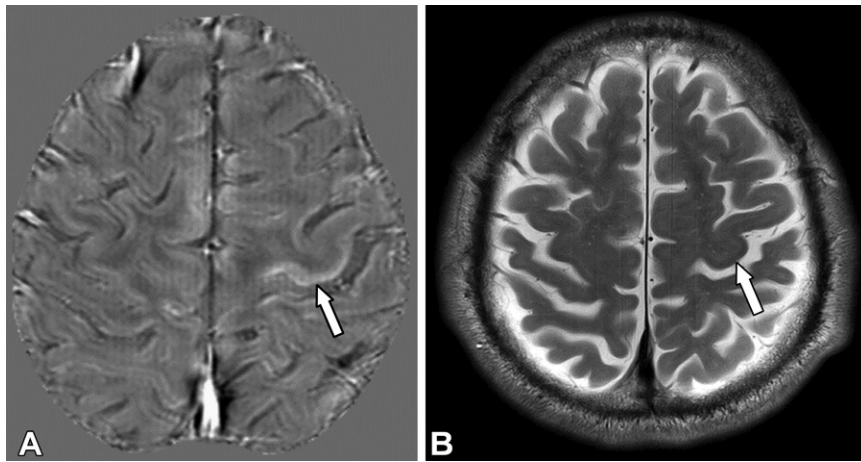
ALS in a 42-year-old woman with slowly progressive muscle atrophy. (A) Axial QSM image demonstrates a high-contrast area (arrow) in the cortex of the left precentral gyrus. (B) Axial T2-weighted MR image demonstrates how the high-contrast area in A is difficult to depict with T2-weighted imaging (arrow).
